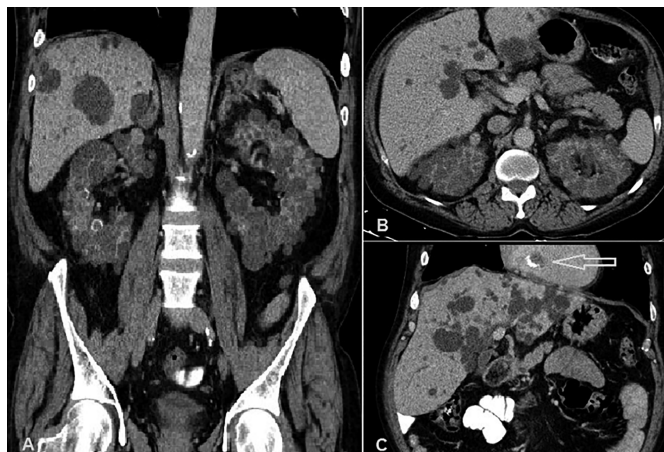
Non-contrast enhanced computed tomography demonstrating multiple cysts in the liver and markedly enlarged bilateral kidneys by innumerable cysts (A-C). Calcific-walled cardiac mass is also noted (arrow).
